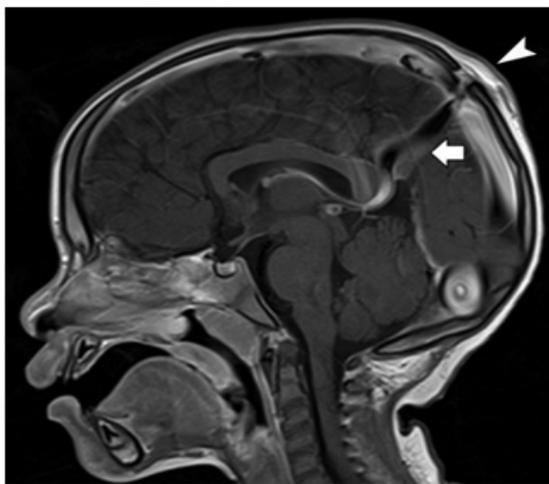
Sagittal T1 weighted MRI with contrast again demonstrating the 15 x 6 x 11 mm midline subcutaneous soft tissue lesion with an underlying calvarial parietal defect measuring 8 mm in diameter with a connection to the superior sagittal sinus (indicated by the white arrowhead). In addition, a persistent falcine sinus was identified (indicated by the white arrow).
